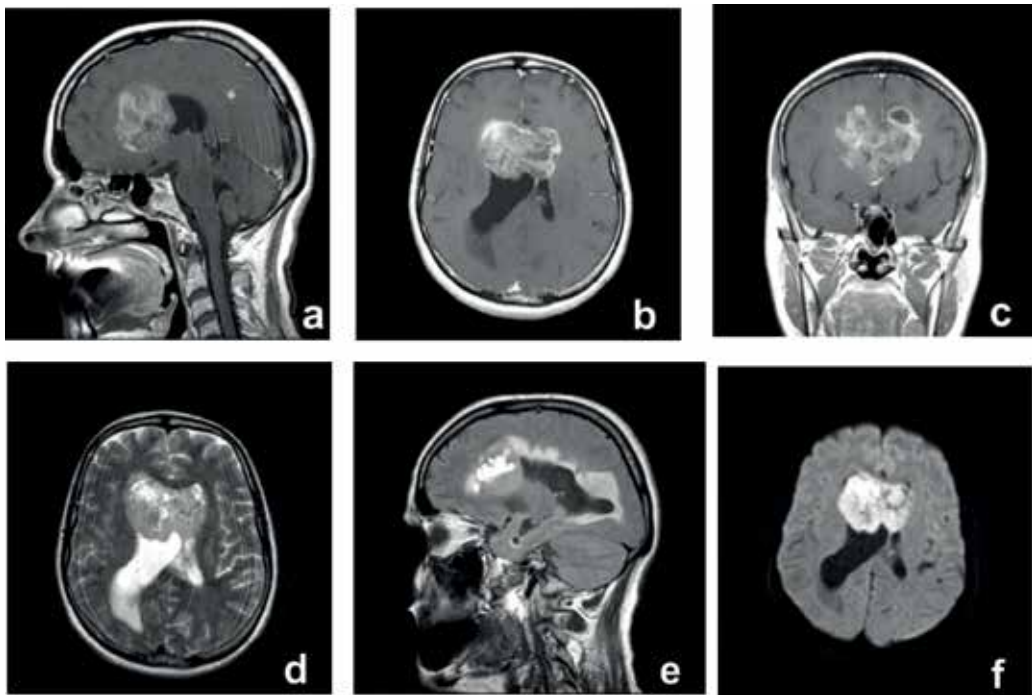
Butterfly glioblastoma – MRI features. Tumor involves both cerebral hemispheres by crossing the corpus callosum – Bifrontal localization. (a) Sagittal T1-weighted image with contrast; (b) axial T1-weighted image with contrast; (c) coronal T1-weighted image with contrast; (d) axial T2-weighted image; (e) sagittal fluid-attenuated inversion recovery (FLAIR) sequence; (f) axial diffusion-weighted image (DWI).
